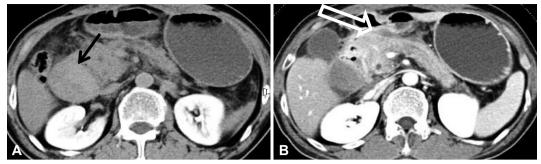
Computed tomography findings. (A) The arrow indicates a highly attenuated mass narrowing the lumen and major distension of the stomach. (B) Blank arrow indicates mild pancreatic swelling with peripancreatic infiltration.
